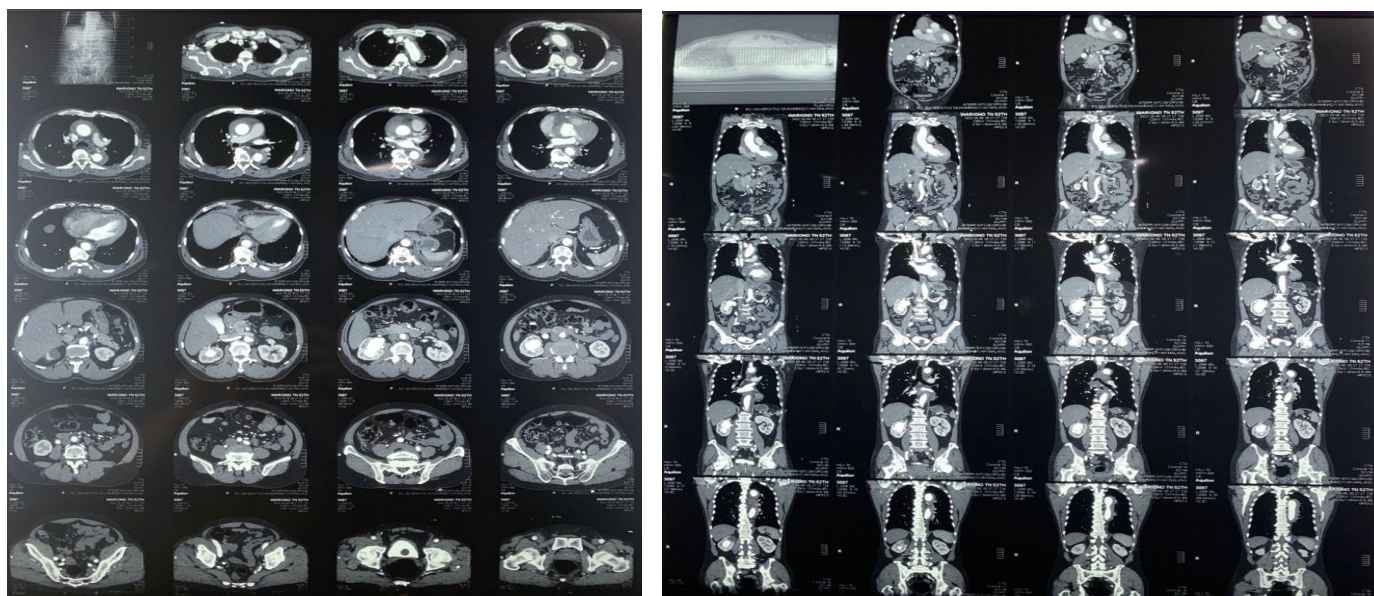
CT angiography intramural hematoma with Stanford A.
